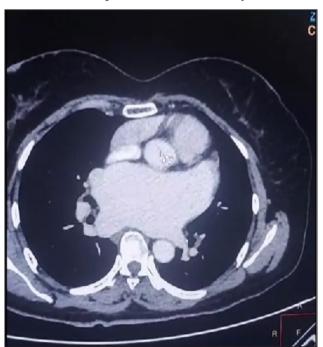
Dilated Left atrium seen in axial view of CT chest.
